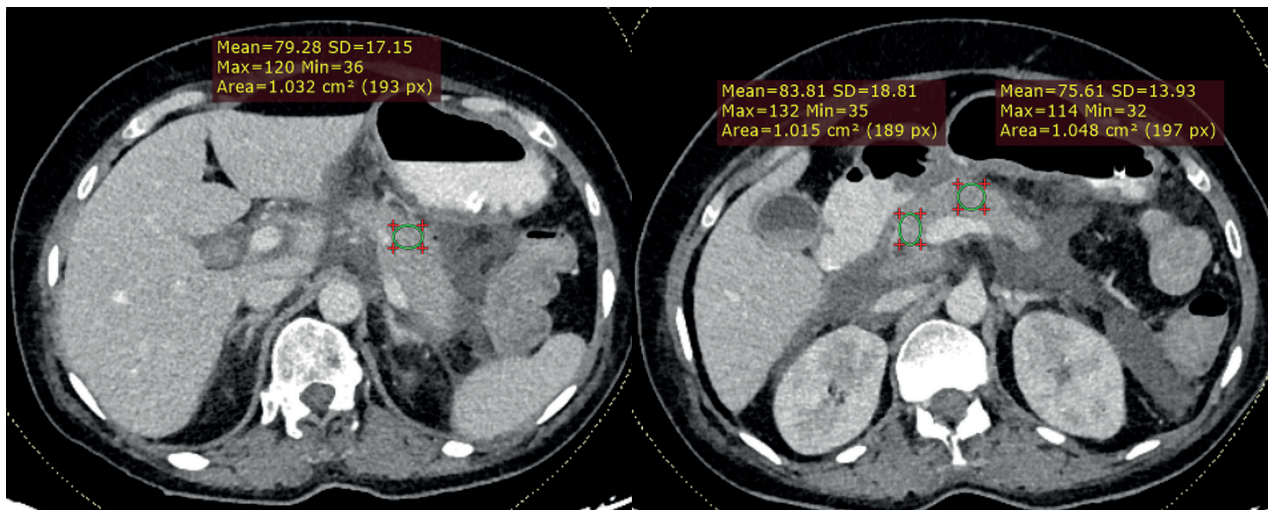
Axial CT images in a 46-year-old patient with gallstone induced acute pancreatitis with isolated EPN. The pancreatic attenuation values were less than 100 HU in the head, body and tail (absolute values given by cursors).
